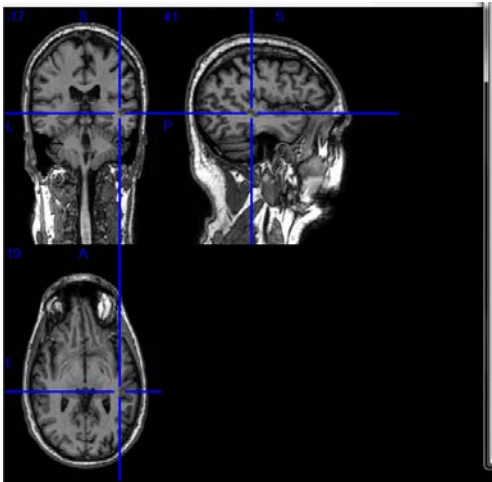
MRI of patient with Alzheimer’s disease [3]
